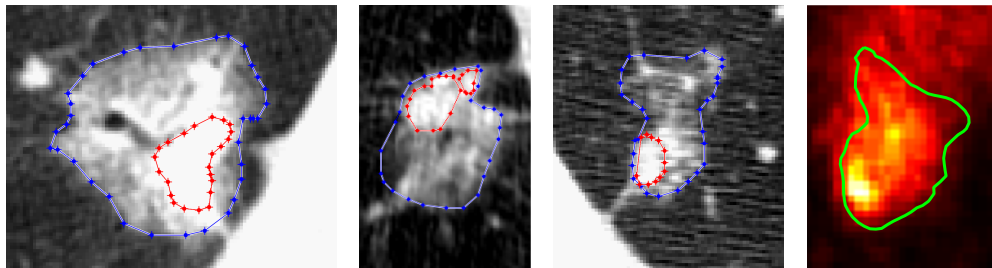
Axial views of heterogeneous NSCLC tumors. The three CT images on the left show tumors with solid (red) and ground glass (blue) regions delineated. The PET image on the right shows the metabolic heterogeneity of the tumor.
